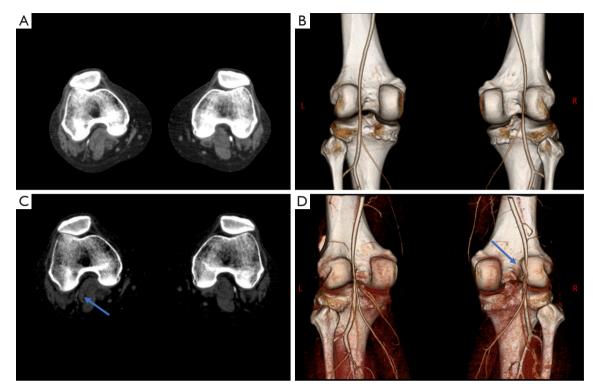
Axial contrast enhanced CT angiogram in the neutral (A) and plantarflexed (C) positions demonstrating bilateral compression and displacement of popliteal artery by the medial head of the gastrocnemius. The right knee (blue arrow) shows greater compression. Coronal CTA reconstructions from the posterior side in the neutral (B) and plantarflexed (D) positions. Complete occlusion of the popliteal artery is shown on the right side (blue arrow).
